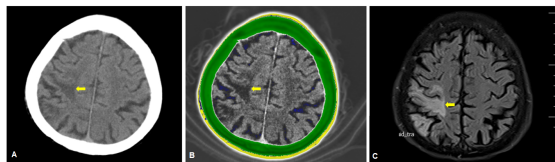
An edematous lesion in right parietal lobe (yellow arrow). (A) unprocessed grayscale CT image; (B) processed color CT image; (C) corresponding T2-FLAIR MRI scan.
